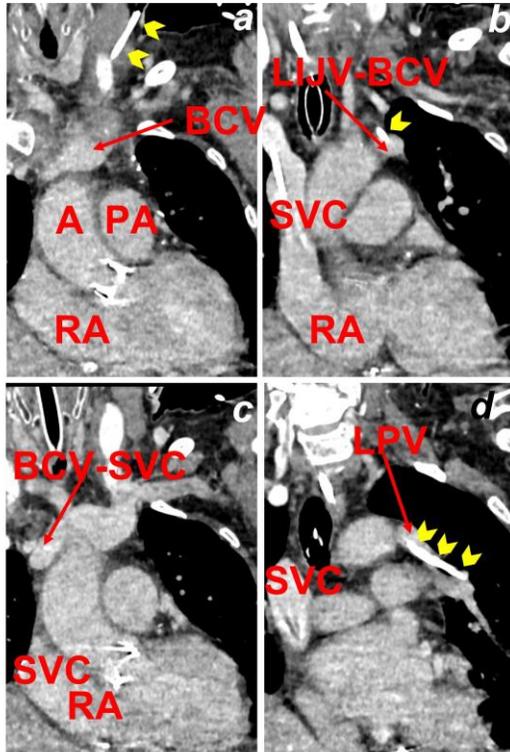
CT images showing communication between BCV and LPV (branch of the left pulmonary vein) in anterior-posterior sequence a-d. A: aorta; LIJV: left internal jugular vein; PA: pulmonary artery; RA: right atrium, SVC: superior vena cava. Arrowheads: CVC line
